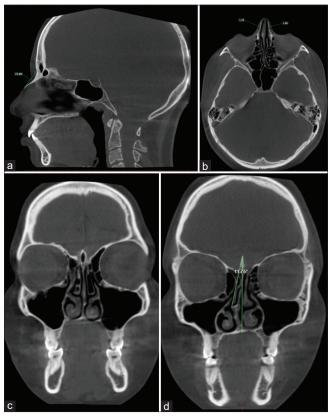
Sections of cone-beam computed tomography showing (a) nasal bone length measurement on sagittal sections from the frontonasal suture to the endpoint of the nasal bone, (b) lateral nasal bone width measurement on axial sections bilaterally at the nasomaxillary suture, (c) concha bullosa evaluation on coronal sections as pneumatization of the middle turbinate to more than half of its length, (d) nasal septal deviation angle measurement on coronal sections as the angle between the most deviated point in the septum and the midline. Midline was defined as the line joining crista galli and crista nasalis
